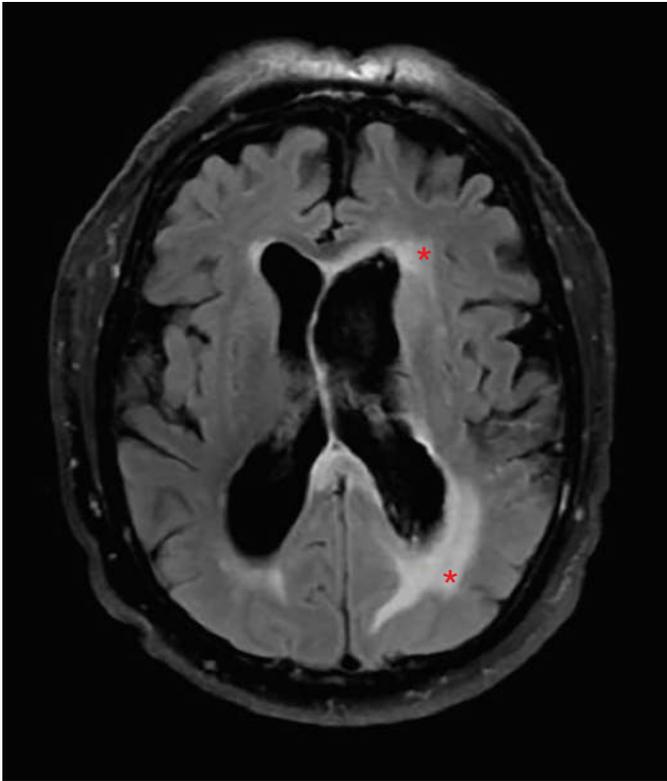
Interstitial edema. FLAIR MRI shows hyperintense fluid signal in the periventricular white matter adjacent to the frontal and occipital horns of the left lateral ventricle (*red asterisks*) in this patient with intraventricular hemorrhage and acute obstructive hydrocephalus.
